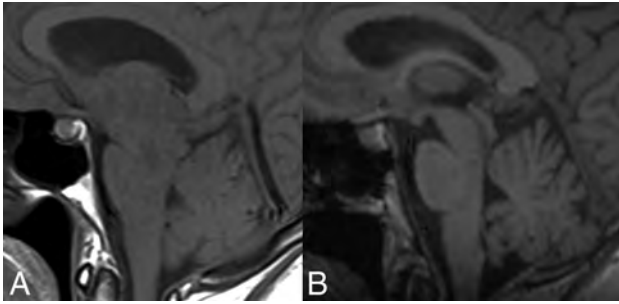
Pre- and posttreatment MRIs of the patient in Fig 2. *A*, Sagittal T1-weighted MR imaging shows brain sag with narrowing of the mamillopontine distance, narrowing of the prepontine cistern, and inferior sloping of the floor of the third ventricle. There is also pituitary enlargement and distension of the straight sinus. *B*, Resolution of these changes following CT-guided injection of fibrin sealant.
